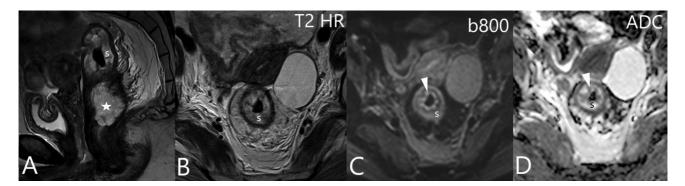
Magnetic resonance imaging (MRI) following total neoadjuvant therapy (TNT) in a patient with mid-rectal cancer. (A) Sagittal and (B) axial T2 high-resolution (HR) MRI shows incomplete response with residual T2 hyperintense mid-rectal cancer (*) and extensive submucosal edema (marked "s"). (C) High *b*-value diffusion-weighted imaging (DWI) (b800) and (D) apparent diffusion coefficient (ADC) map shows the submucosa (s) with facilitated diffusion and mucosa (arrowhead) with restricted diffusion from mucosal necrosis.
